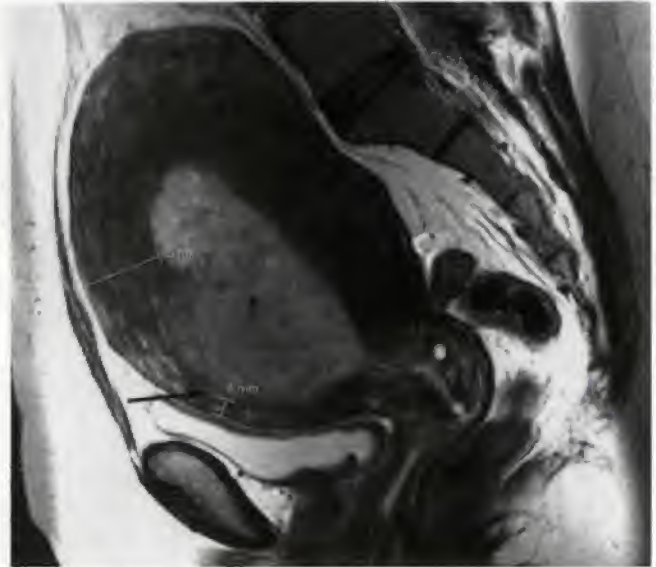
Stage IB endometrial cancer. Gadolinium-enhanced sagittal T1-weighted image demonstrating expansion of the endometrial cavity by an enhancing mass (asterisk) and associated focal superficial invasion of the myometrium anteriorly (arrow).
